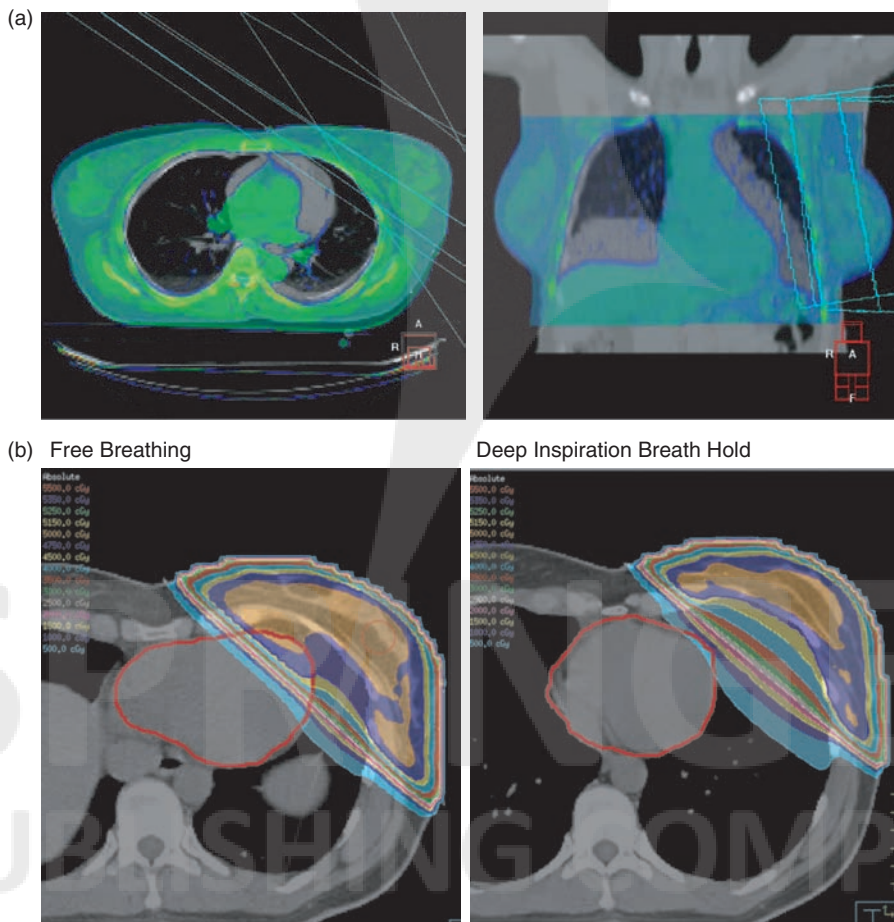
Deep inspiration breath hold technique. Match of the free breathing (gray) and deep inspiration breath hold (green) CT scan. During inspiration, the heart has moved caudal and dorsal. Radiotherapy can be planned without significant reduction in heart dose.
